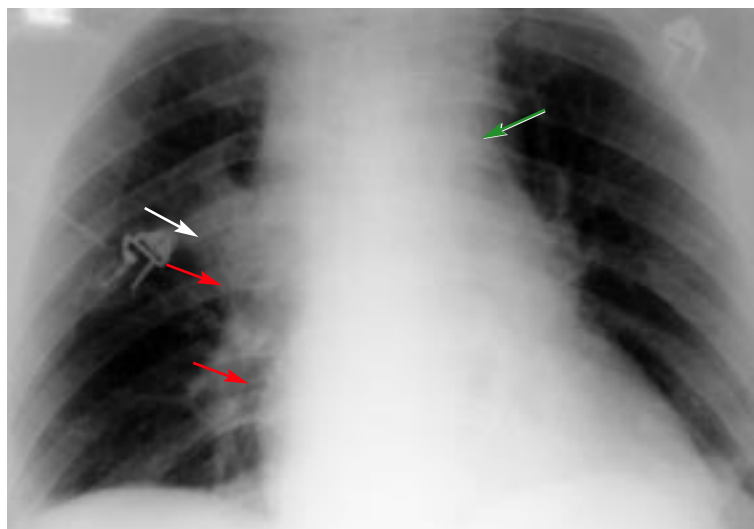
A repeat chest radiograph shows a right hilar and right paramediastinal prominence (white arrow), possible right hilar mass or infiltrate (red arrow), and peritracheal lymphadenopathy (green arrow).
